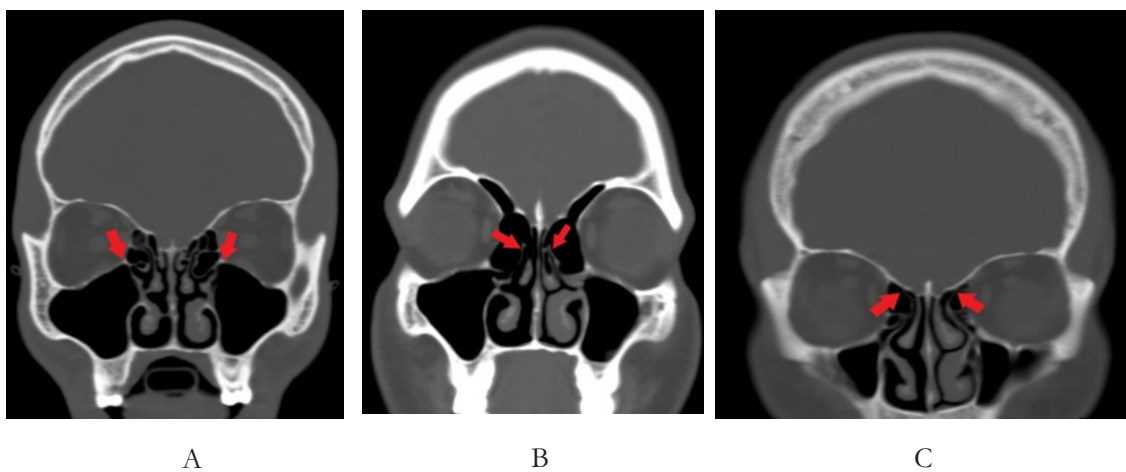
(Original) Reformatted Coronal CT images of the skull (bone window) depicting the superior attachment of the uncinata process A. On lamina papyracea B. On middle turbinate C. On skull base
